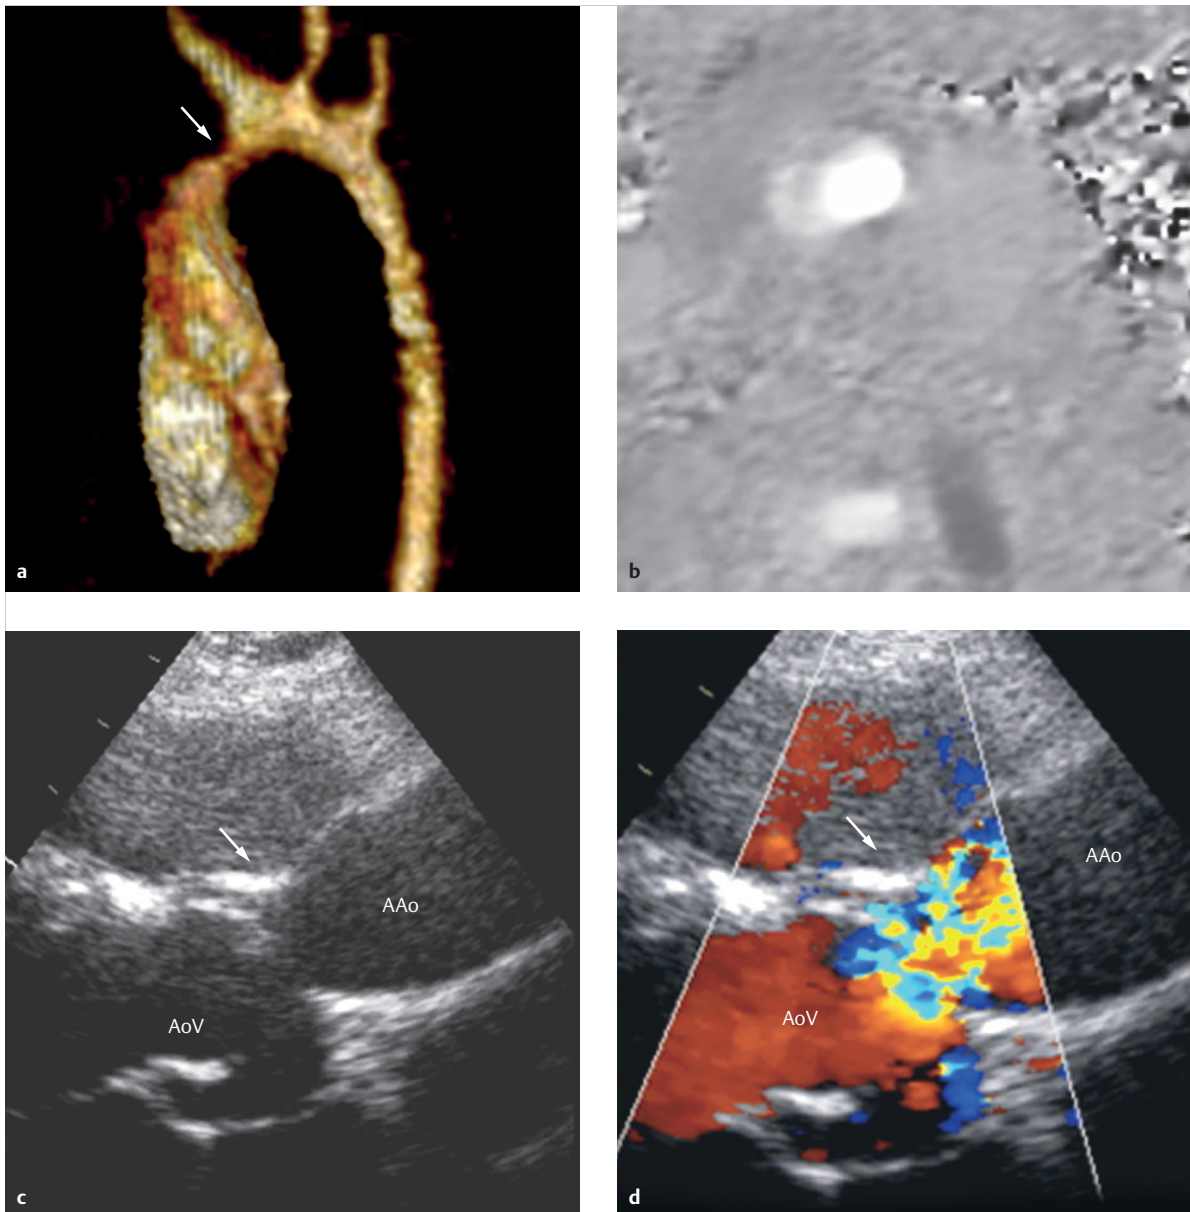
Supravalvular aortic stenosis. Two patients. Two-month-old infant with hypoplastic aortic arches, condition after surgical reconstruction of the aortic arch (a, b). Residual stenosis near the ascending aorta (a, arrow). A 2-D TTE image, parasternal long axis, of another patient with supravalvular aortic stenosis (c, d) clearly shows the supravalvular membrane (arrows) and flow acceleration in color Doppler.
